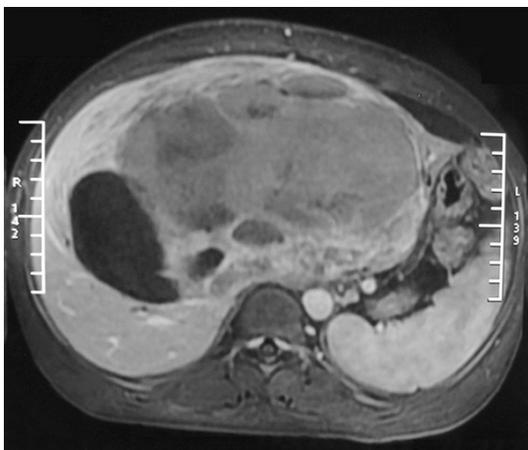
MRI scan revealed a well-defined, cystic mass located in the left three lobes of liver.
